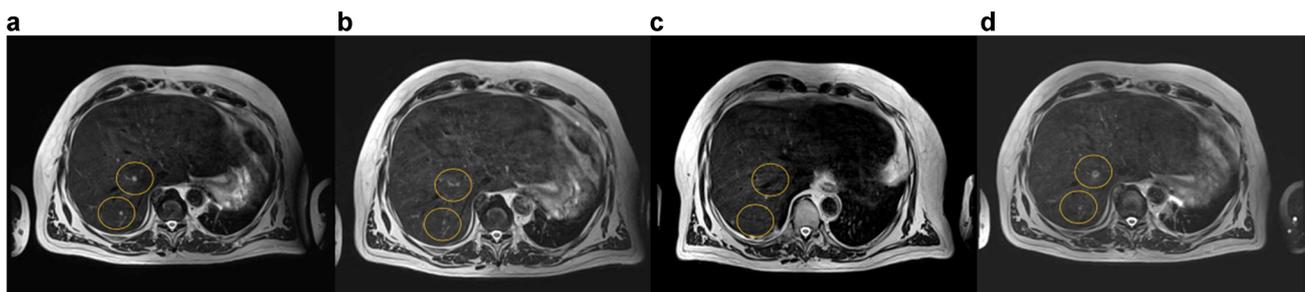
Magnetic resonance imaging (T2 weighted sequences) of liver metastases in a patient with adrenocortical carcinoma submitted to artemisinin: a baseline condition April 2017, b July 2017 after
